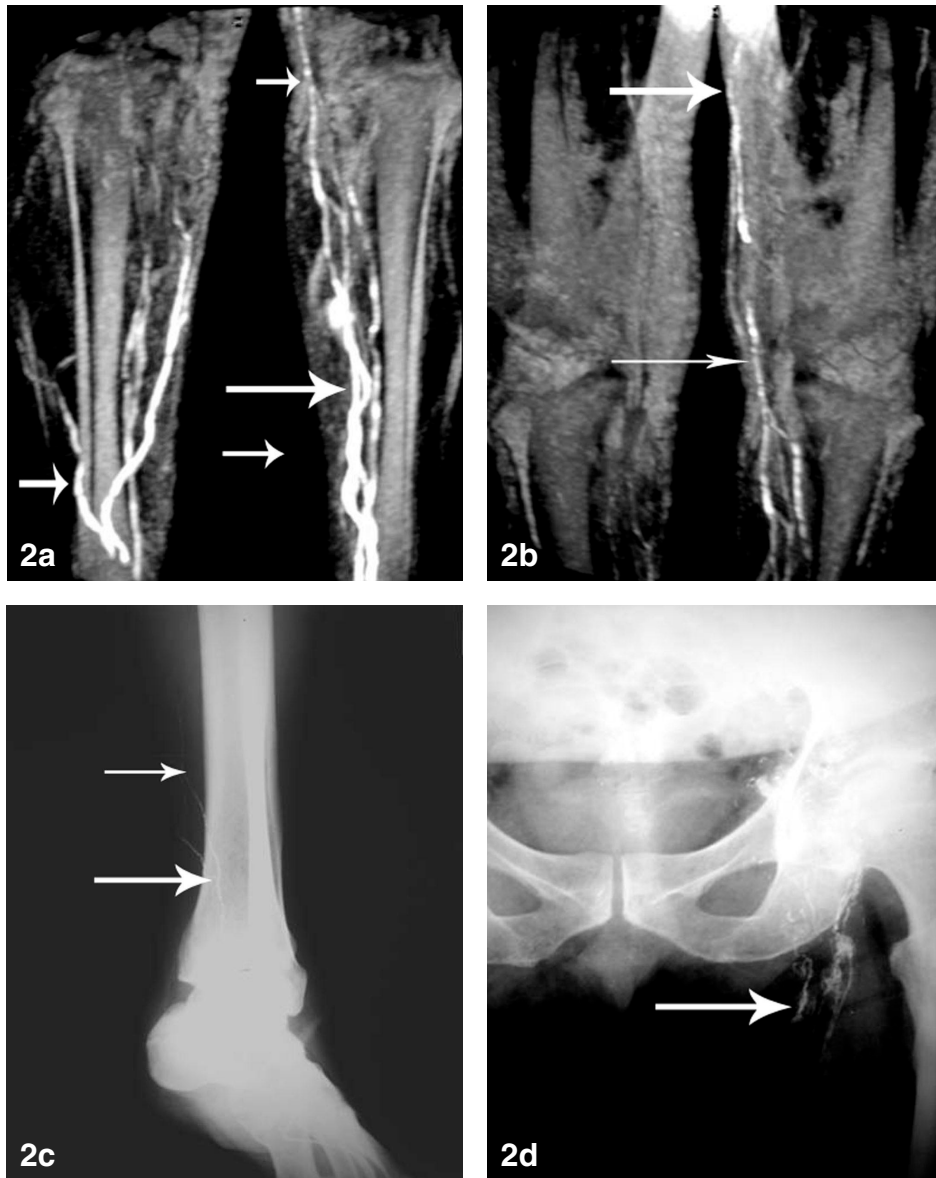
Decreased number of lymph vessels (white arrows) in both legs seen by IMRL (a,b) and confirmed by direct x-ray lymphography (c,d) in a subject with lymphedema (No. 3 from Table 1).
